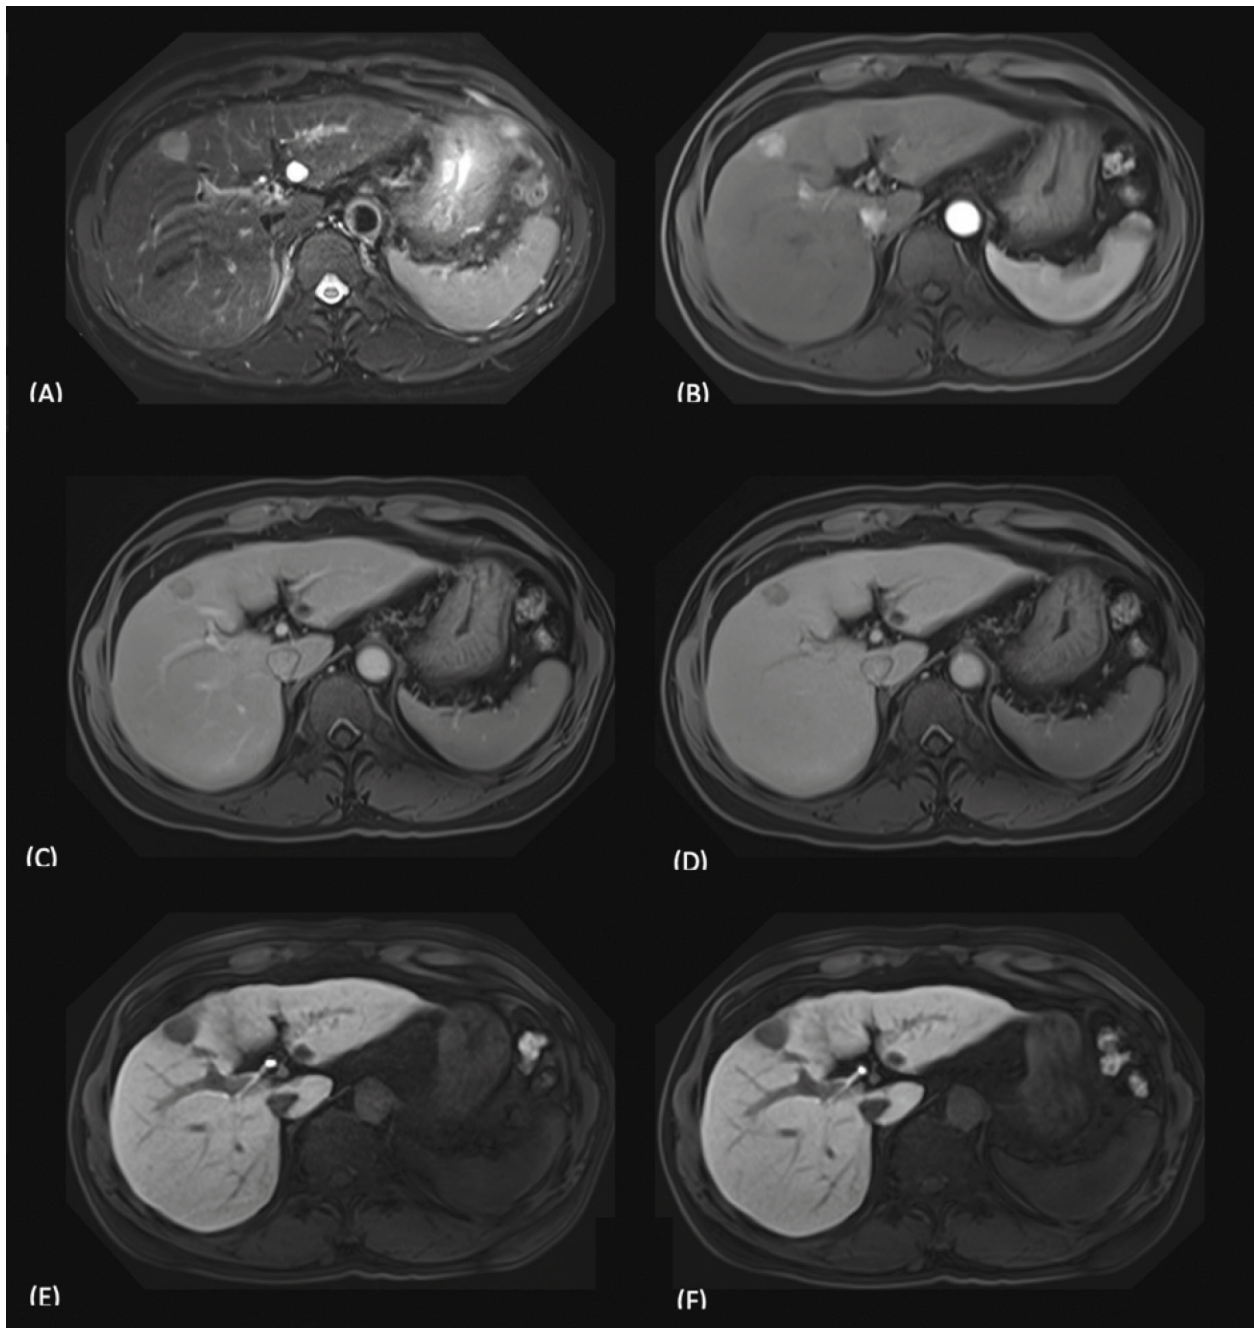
A 56-year-old male with chronic hepatitis C cirrhosis and pathologically proven HCC at hepatic segment IVb/V. Gadoteric acid enhanced liver MRI revealed a 1.7 cm well-defined nodule at hepatic segment IVb/V which showed hyperSI on T2W (A) with arterial enhancement (B) and washout on portovenous (C) and transition phases (D). (E) and (F) showed hypoSI on 15min-FA30 and 20min-FA25 HBIs, respectively.
